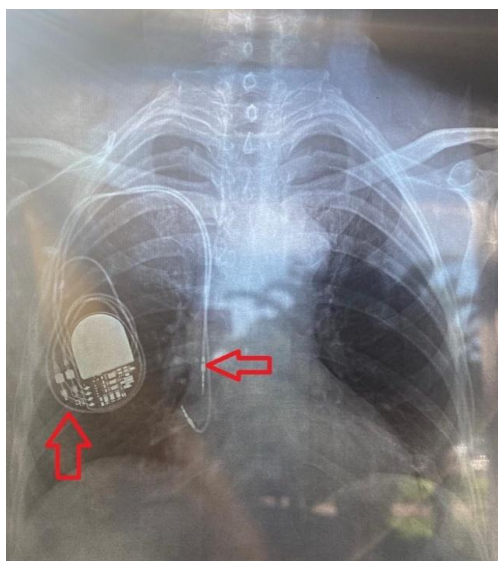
X-ray showing the pulse-generator with twisted ventricular lead around it and retracted ventricular lead (red arrows)
